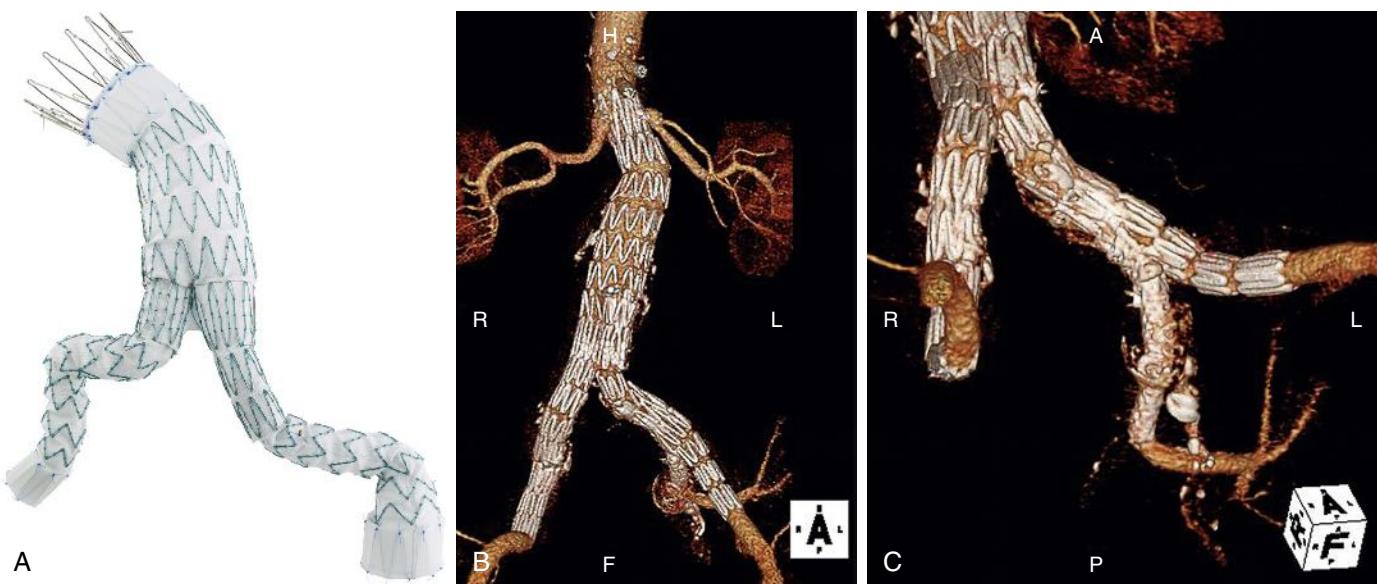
Zenith Iliac Branch Graft. (A) Picture of the iliac branch graft (Cook Medical, Bloomington, IN). (B) Computed tomographic angiography (CTA) of aortic stent graft and iliac branch graft. (C) CTA of iliac branch graft.
